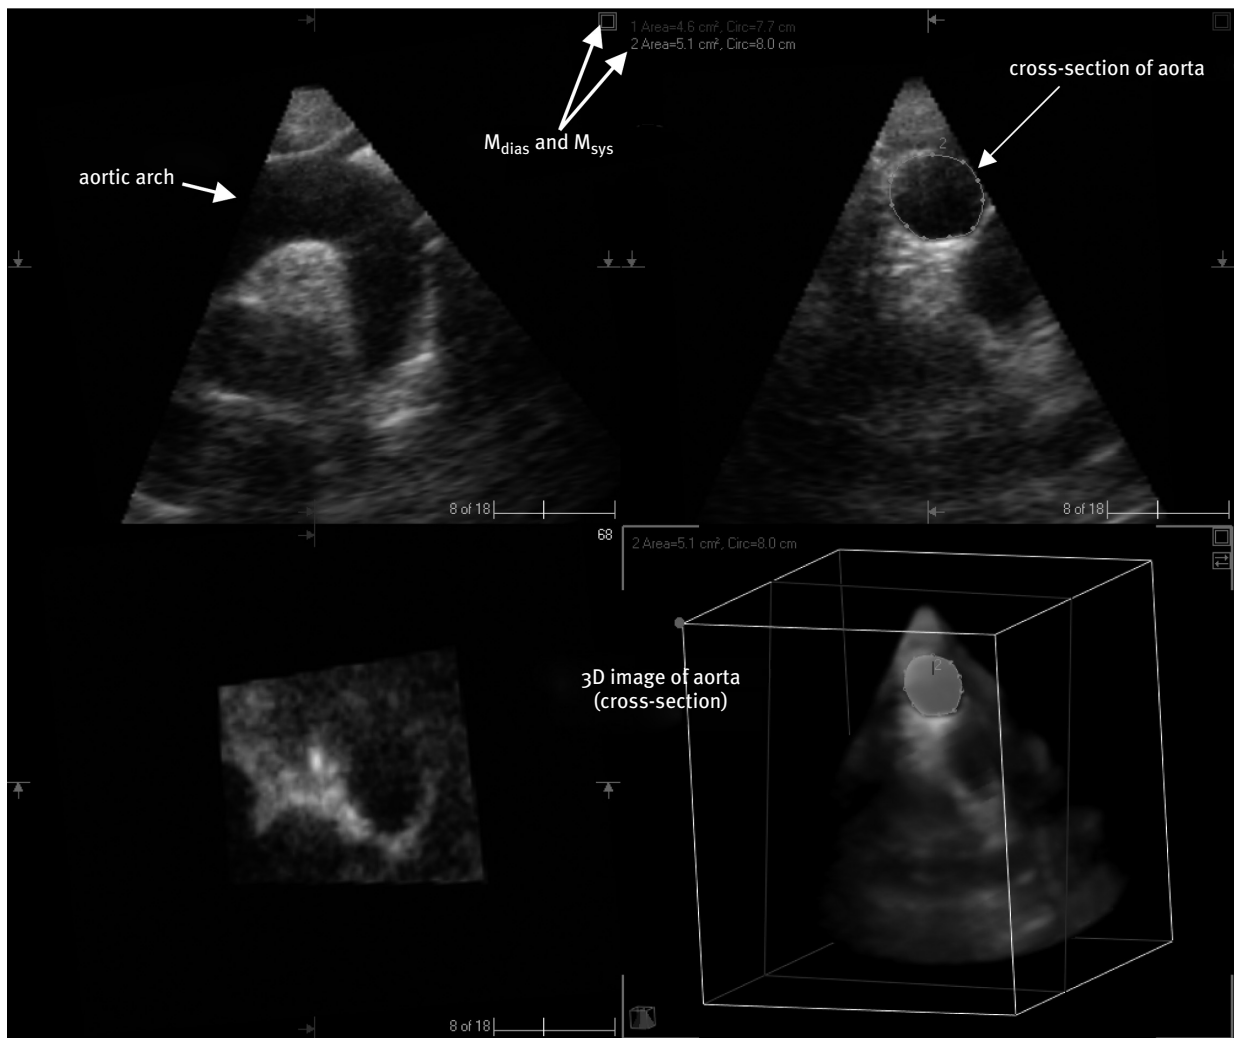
Real-time, 3-D echocardiography allows the exact measurement of shape and surface changes during a heart cycle at each level of the aorta. Abbreviations: M_{dias} = diastolic measurement of aortic surface in cm², M_{sys} = systolic measurement of aortic surface in cm².
